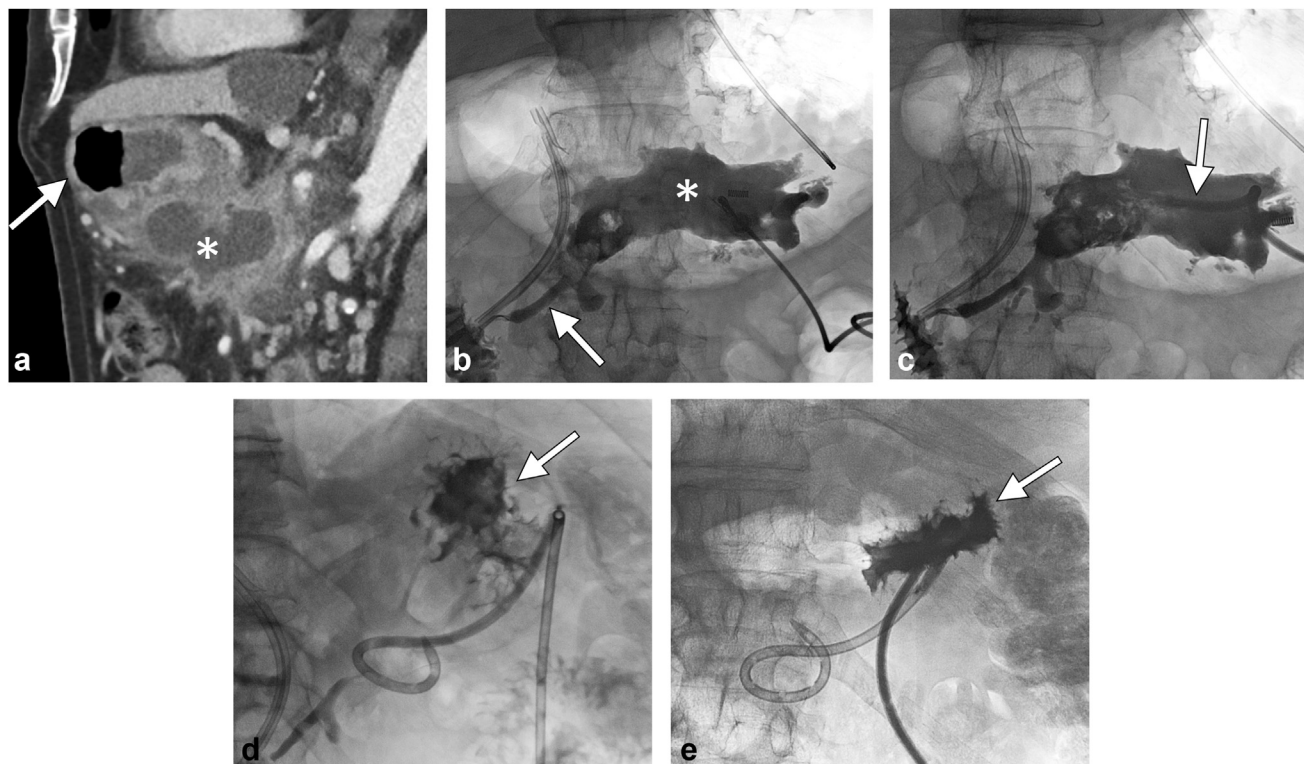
Primary transgastric drain placement. (a) A preprocedural computed tomography scan in the sagittal plane demonstrated walled-off necrosis (asterisk) posterior to the stomach (arrow) in this patient with necrotizing pancreatitis. (b) After single point gastropexy, a needle was advanced through the stomach and into the collection (asterisk) and contrast was injected. The collection was communicating with the pancreatic duct (arrow). (c) After advancing a wire into the collection and performing serial dilation, a drain was placed in the collection (arrow). (d) The patient was later converted to an internal/external drain with side holes in the stomach (arrow). There was a persistent fistula to the pancreatic duct. (e) After an additional 2 months, the collection and fistula resolved, with contrast only opacifying the stomach via communicating side holes (arrow). The drain was removed, and the patient has not had a recurrent collection in 4 years of follow-up.
